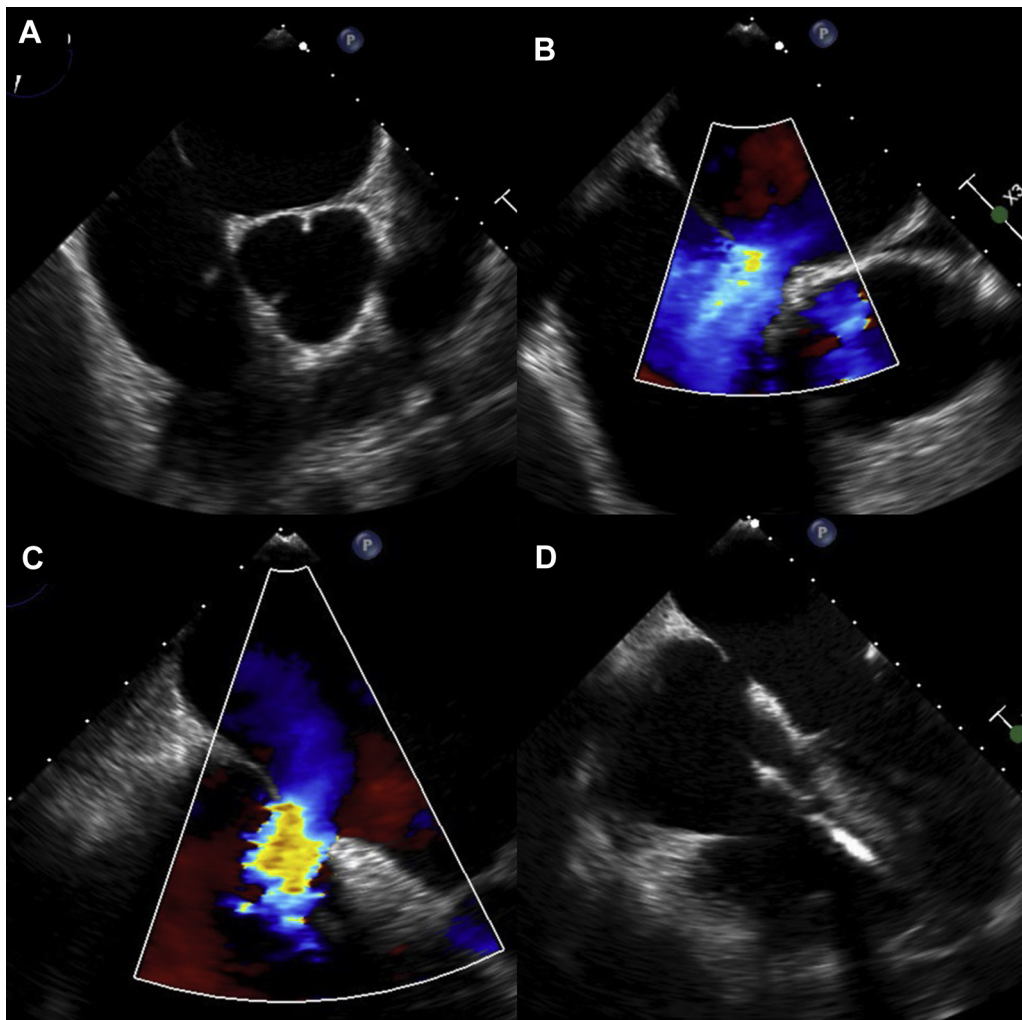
Follow-up transesophageal echocardiogram from case 2 (20 months after cryoballoon ablation) demonstrates a persistent iatrogenic atrial septal defect (A–C) and right ventricle enlargement (D).
